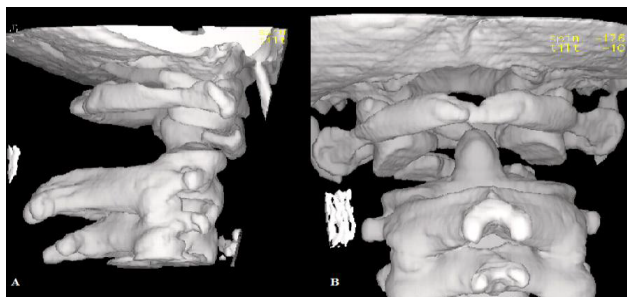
(A) Lateral and (B) Postero-anterior 3D reconstruction CT-scan showing gross C1-C2 dissociation.
